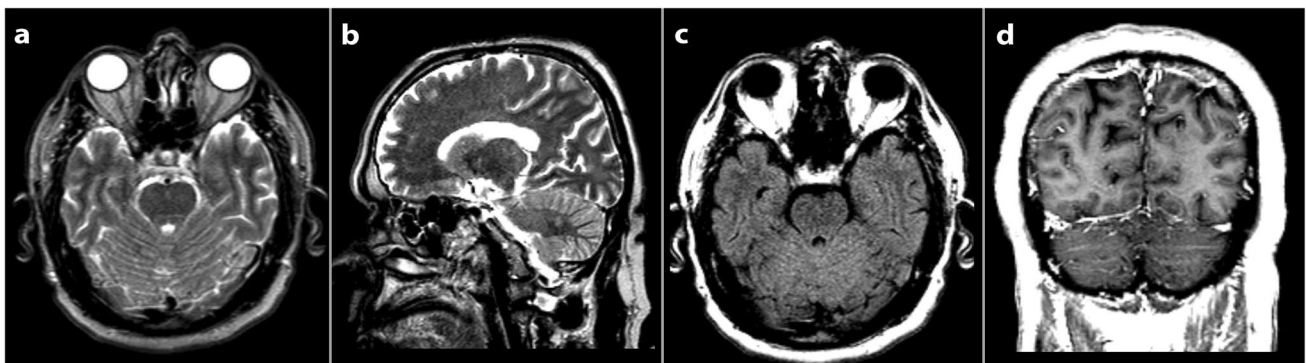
Brain MRIs show edematous hyperintense changes in T2-weighted and FLAIR images in the cerebellum (a, b, c) and cerebellar pial contrast enhancement (d)
